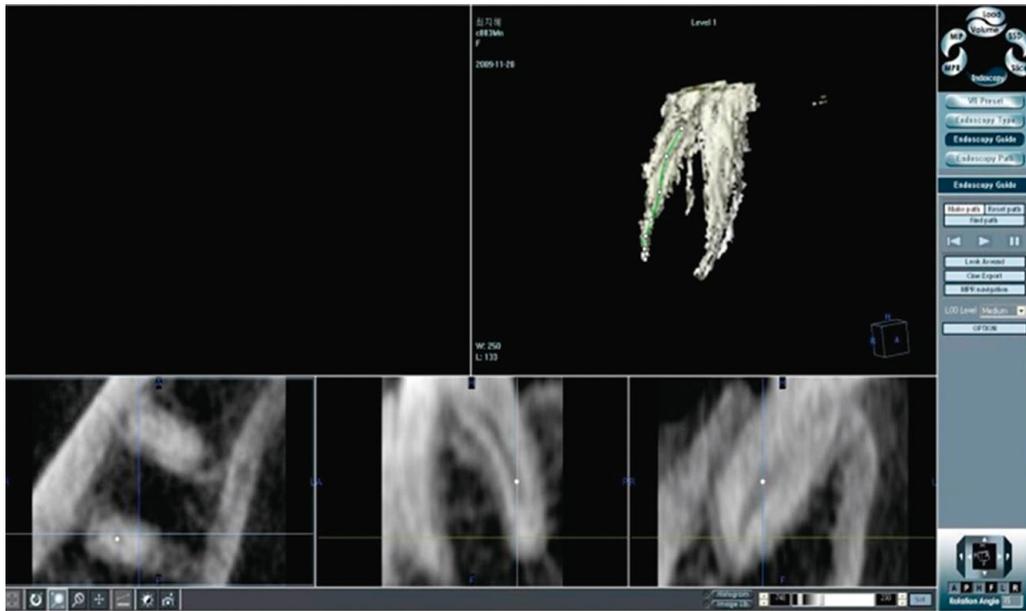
We sliced CT images into 15-20 slices and decided central axis using V-works program.
